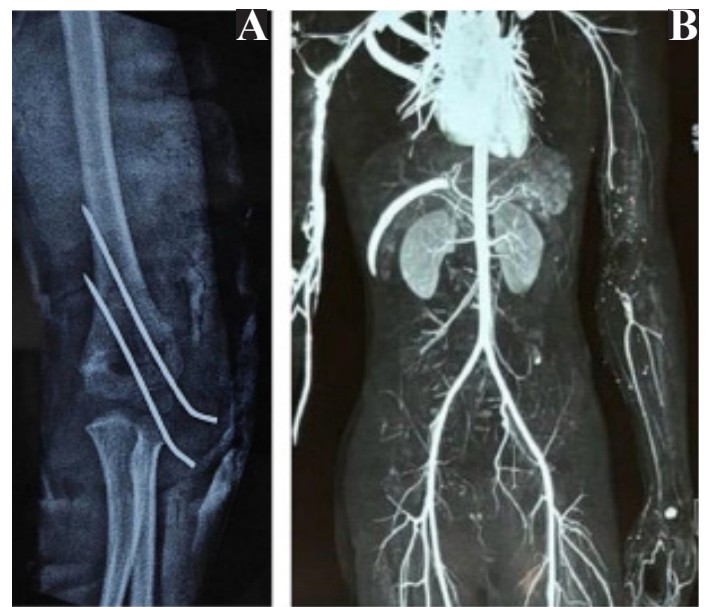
A. X-ray of the left arm with elbow showing K-wire fixation in situ for supracondylar humerus fracture; B. CT angiography showing cut-off of the left brachial artery
